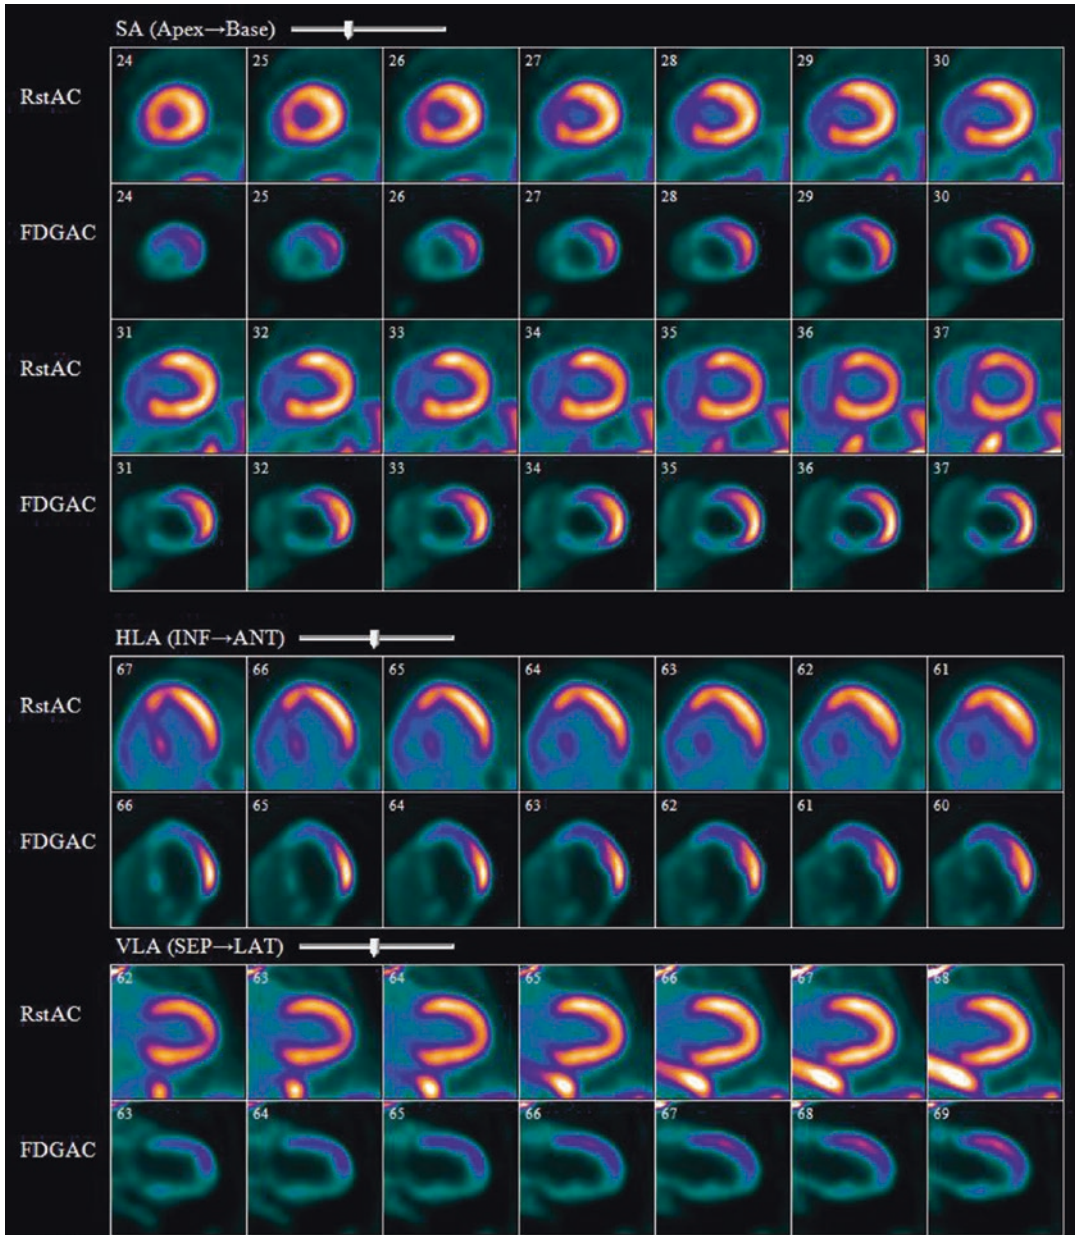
Example of Rb-82 perfusion and active inflammation using F-18 FDG in suspected sarcoid
